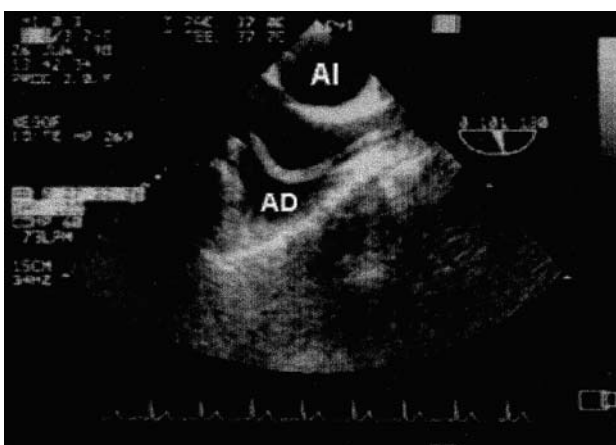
Superior transesophageal plane: tortuous high density image of thrombus which extends into the right atrium (RA) and originating in the superior vena cava. LA indicates left atrium.
